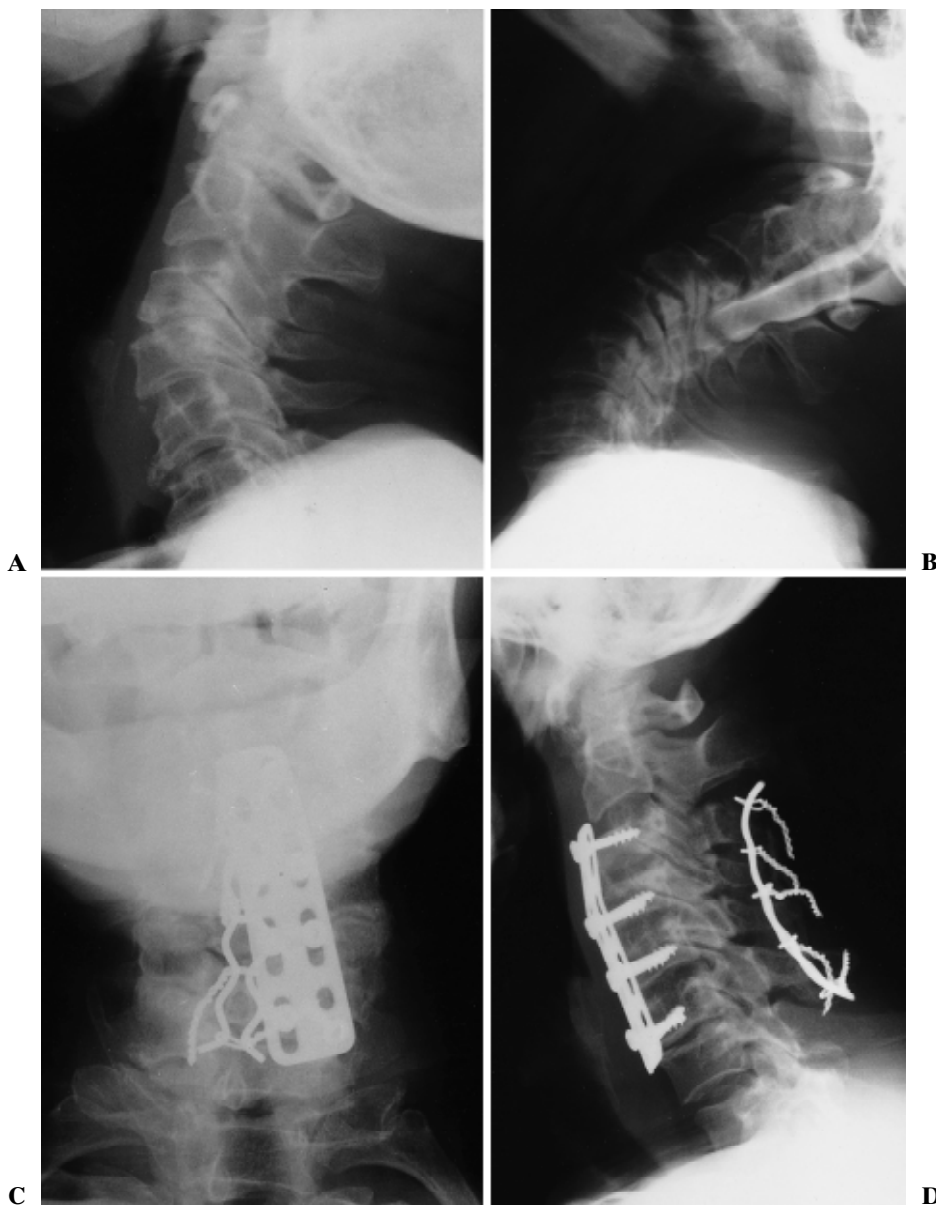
Roentgenograms of case 11. A Lateral view and B myelogram showing instability, malalignment, and bony spurs that compressed the dural tube between C3 and C6. C Anteroposterior and D lateral radiographs made 8 years after the anterior posterior cervical fusion, revealing decreased retrolisthesis by the spreading of the interspinous space between the third and fourth cervical levels; resection of posterior bony spurs; complete bony union; and correction of malalignment
